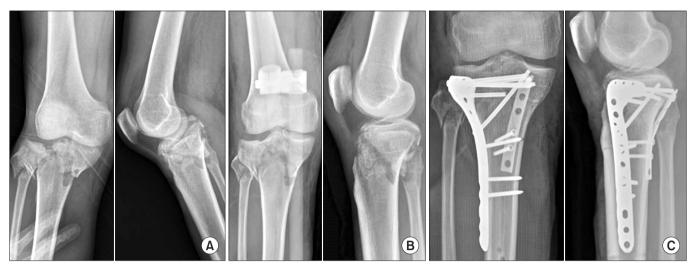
Radiographs of case no. 19 presented in Table 1. (A) A 60-year-old male patient was injured in a pedestrian traffic accident and suffered a tibial plateau fracture (Schatzker type VI) as well as a fracture of the fibula. (B) A temporary external fixator was immediately applied after injury. (C) Six days after the first operation, dual plating using medial and lateral approaches was applied.
